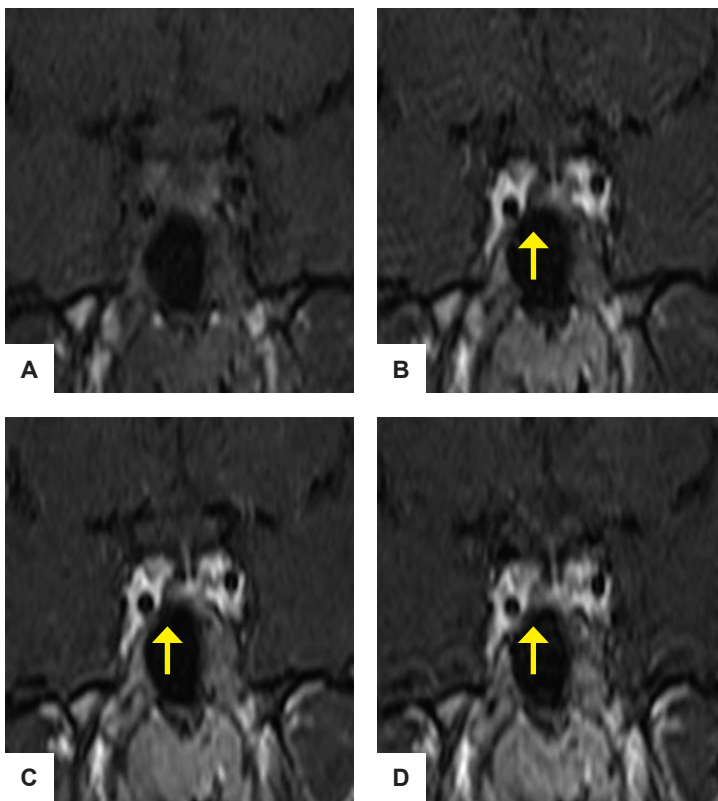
Pituitary MRI. High-resolution pre-contrast (A) and selected dynamic contrast enhance T1 (B), (C), and (D) at 39 seconds, 64 seconds and 89 seconds post-gadolinium respectively. The pituitary gland does not show any distinct lesion on the pre-contrast image. In the dynamic post-contrast sequence, a distinct area of delayed enhancement at the right side of the pituitary gland represents the microadenoma (yellow arrow). A subtle displacement of the pituitary stalk to the left and mild inferior bulging of the sellar floor on the right side indicates the presence of a mass in the right pituitary gland.
